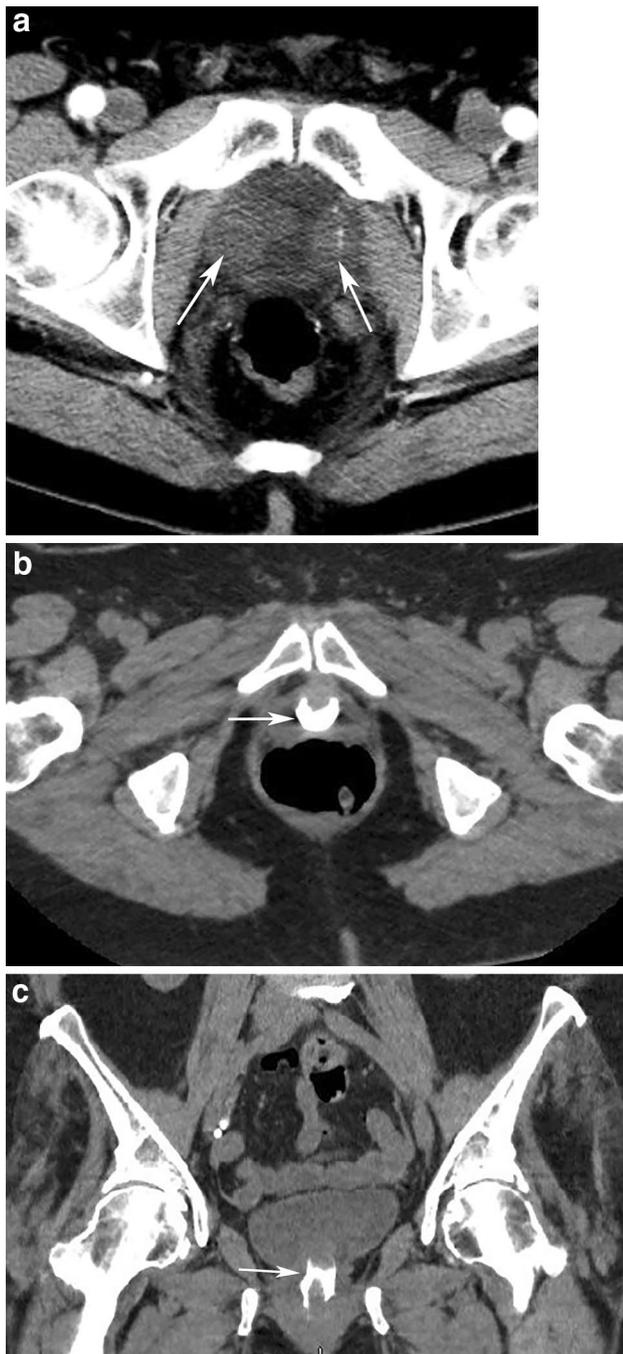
Injection of a urethral bulking agents. a An axial arterial phase contrast-enhanced CT image through the pelvis in this patient who previously had a prostatectomy and who currently has undetectable prostate specific antigen levels shows lobulated masses on either side of the bladder neck (arrows), with calcification on the left. Upon further investigation of the patient's electronic medical record, it was determined that the patient had previously undergone injection of a urethral bulking agent for treatment of incontinence. Coronal imaging can be helpful to localize the abnormality. b An axial portal venous phase contrast-enhanced CT image through the pelvis in a different female patient with incontinence demonstrates high attenuation material in a crescentic shape in the periurethral region, consistent with the carbon-coated bead type of bulking agent. c A coronal image from this same female patient's CT helps localize the agent
